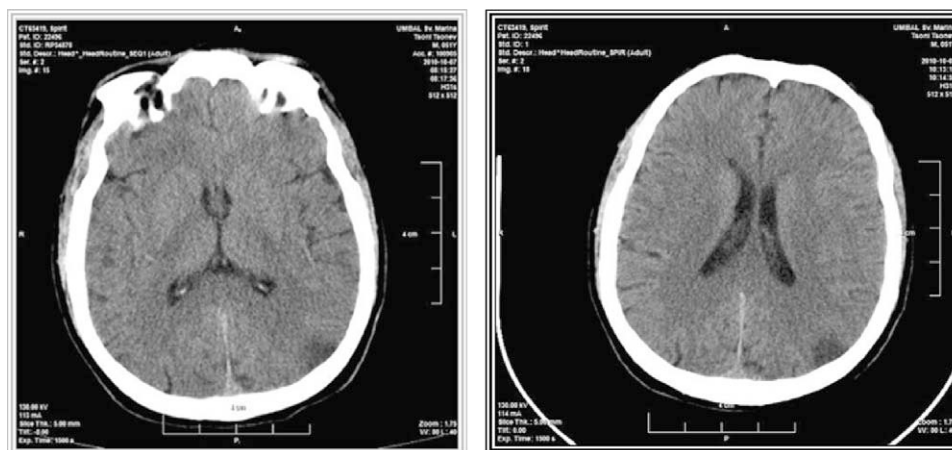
Control CT (10.15h) to exclude intracerebral hemorrhage NIHSS = 15.
